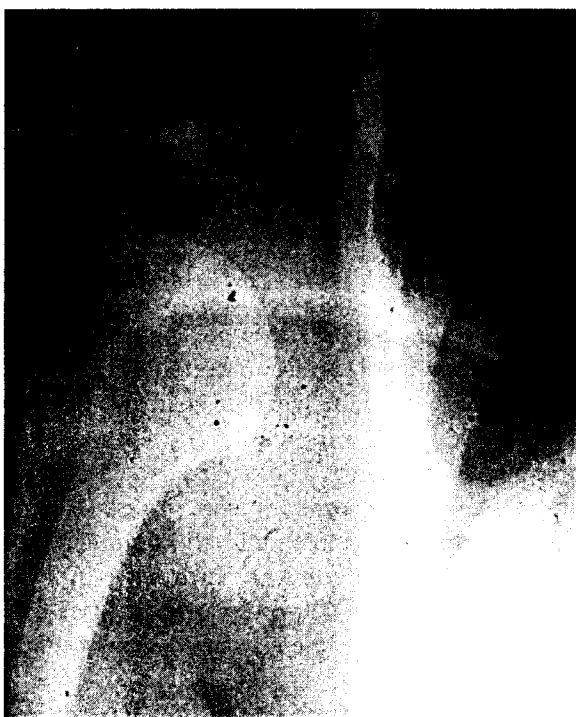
Anteroposterior radiograph of the shoulder demonstrating a glenohumeral dislocation.
